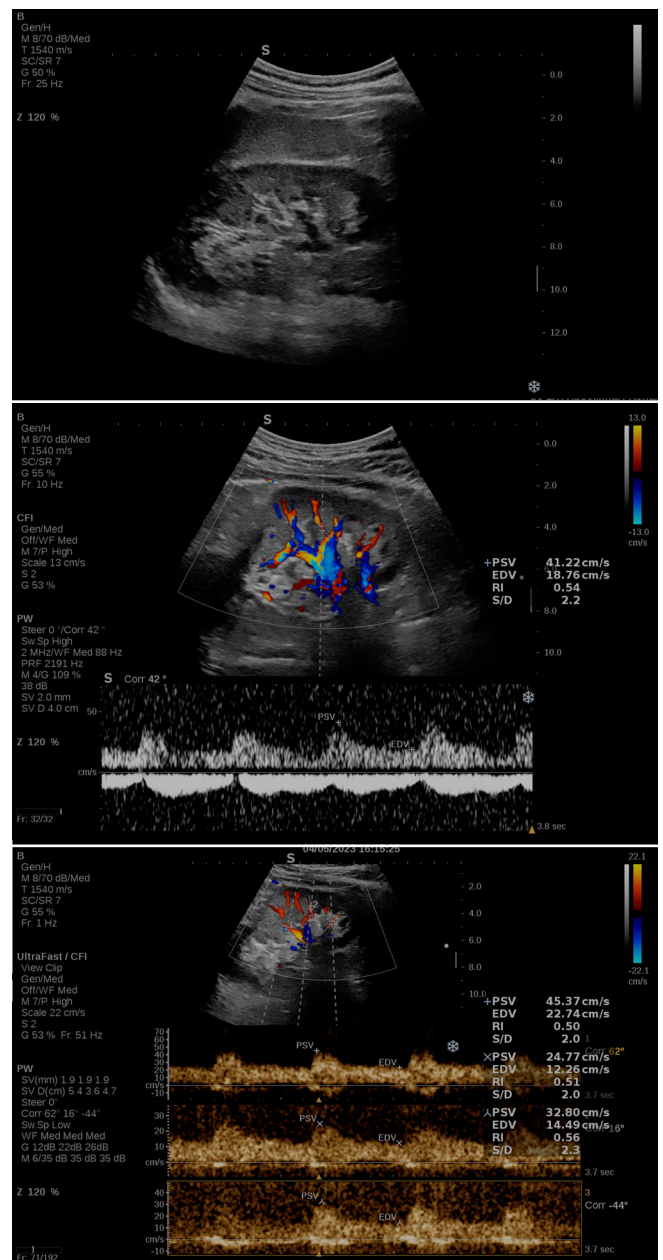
The kidneys were first visualized using B-mode ultrasound (upper image). Conventional color Doppler imaging was then performed with pulse-wave spectral analysis (middle image). Next, UltraFast™ acquisition was performed with spectral analysis of segmental arteries (lower image)
